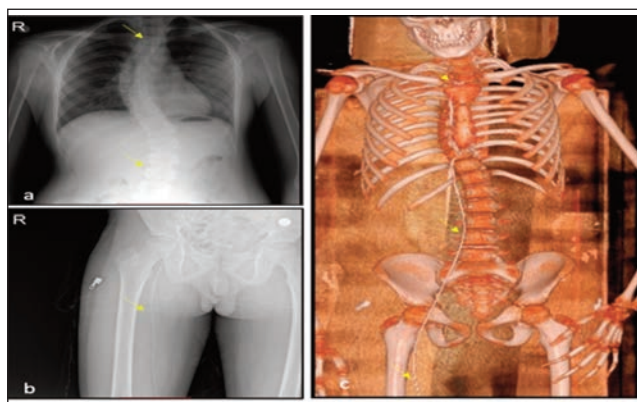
Radiograph and computed tomography (CT) images of the patient. Radiograph of the (a) chest and abdomen showing the foreign body extending up to the superior vena cava in the paravertebral area, (b) pelvis and femur showing it in the femoral vein. (c) Three-dimensional CT image showing the foreign body extending from the femoral vein to the superior vena cava, indicated by the yellow arrow, consistent with the guidewire.
